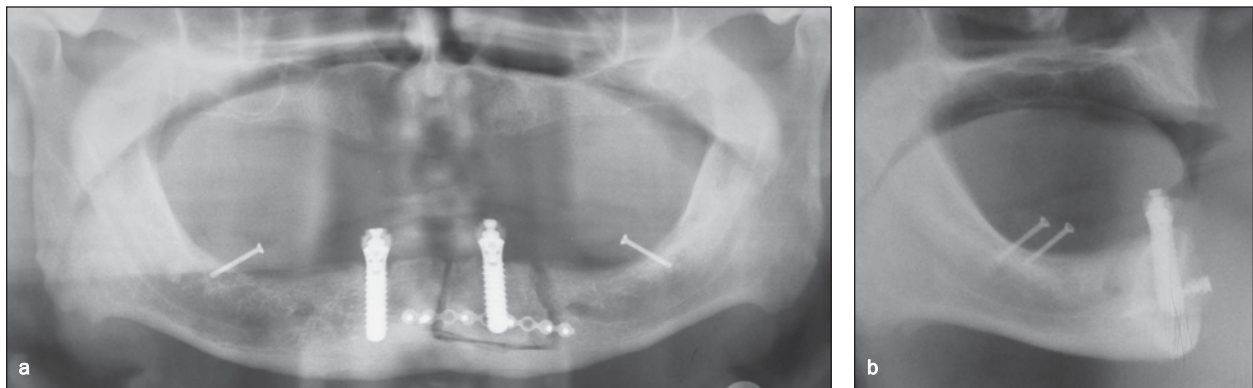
Radiographic images immediately postsurgery. (a) Orthopantomogram showing the osteotomy lines. The osteotomized part was fixed with a miniplate to the mandible. Stabilization of the segment was achieved by fixing the template to the implants (abutments) and jaw (screws). (b) Lateral cephalogram showing that the left implant is realigned.
